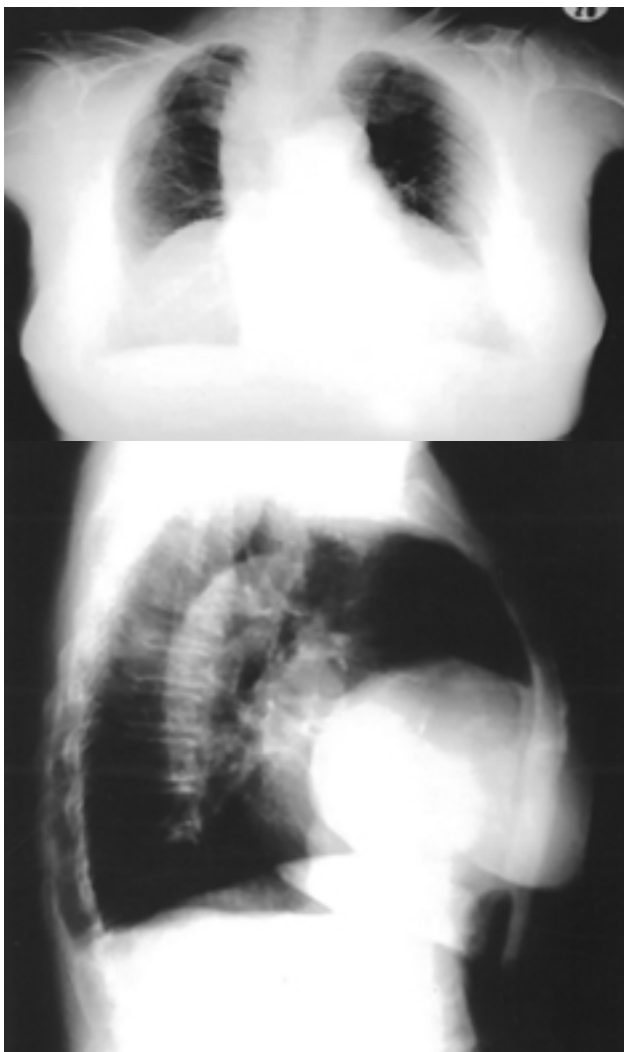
Posteroanterior chest X-ray showing a homogeneous increase in opacity, 9 cm in diameter and regularly delineated at the right para-cardiac area
